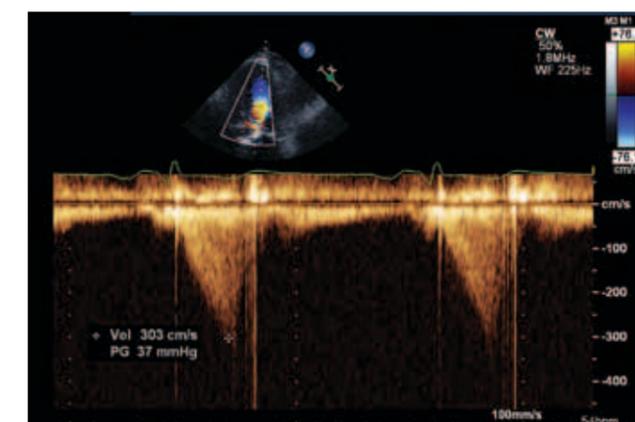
This CW Doppler profile was recorded in a patient with concentric LVH secondary to HTN. This profile is consistent with dynamic LVOT obstruction as evident by the characteristic systolic late-peaking and dagger-shaped profile of this signal. The peak velocity is 3 m/s yielding a gradient of 37 mmHg.
